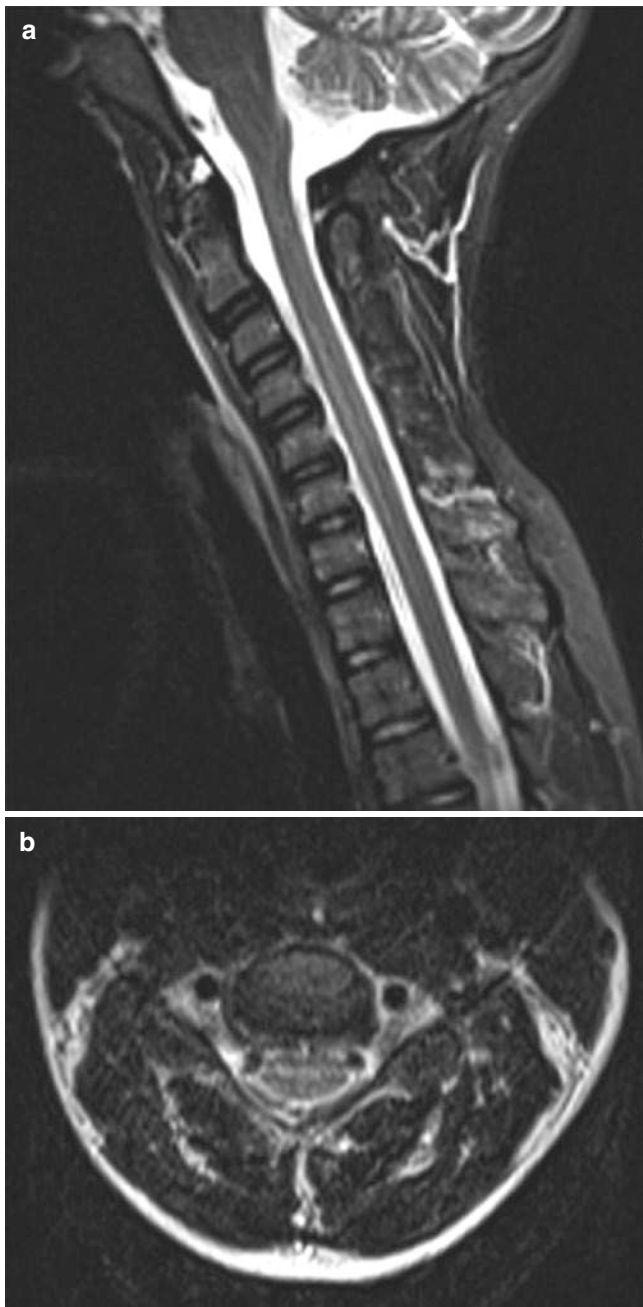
Myelitis secondary to Enterovirus D68 infection. (a) Sagittal STIR MR image shows mild hyperintense signal and minimal swelling of the cervical spinal cord. (b) Axial T2-weighted MR image confirms the presence of abnormal hyperintense signal involving the anterior spinal cord
